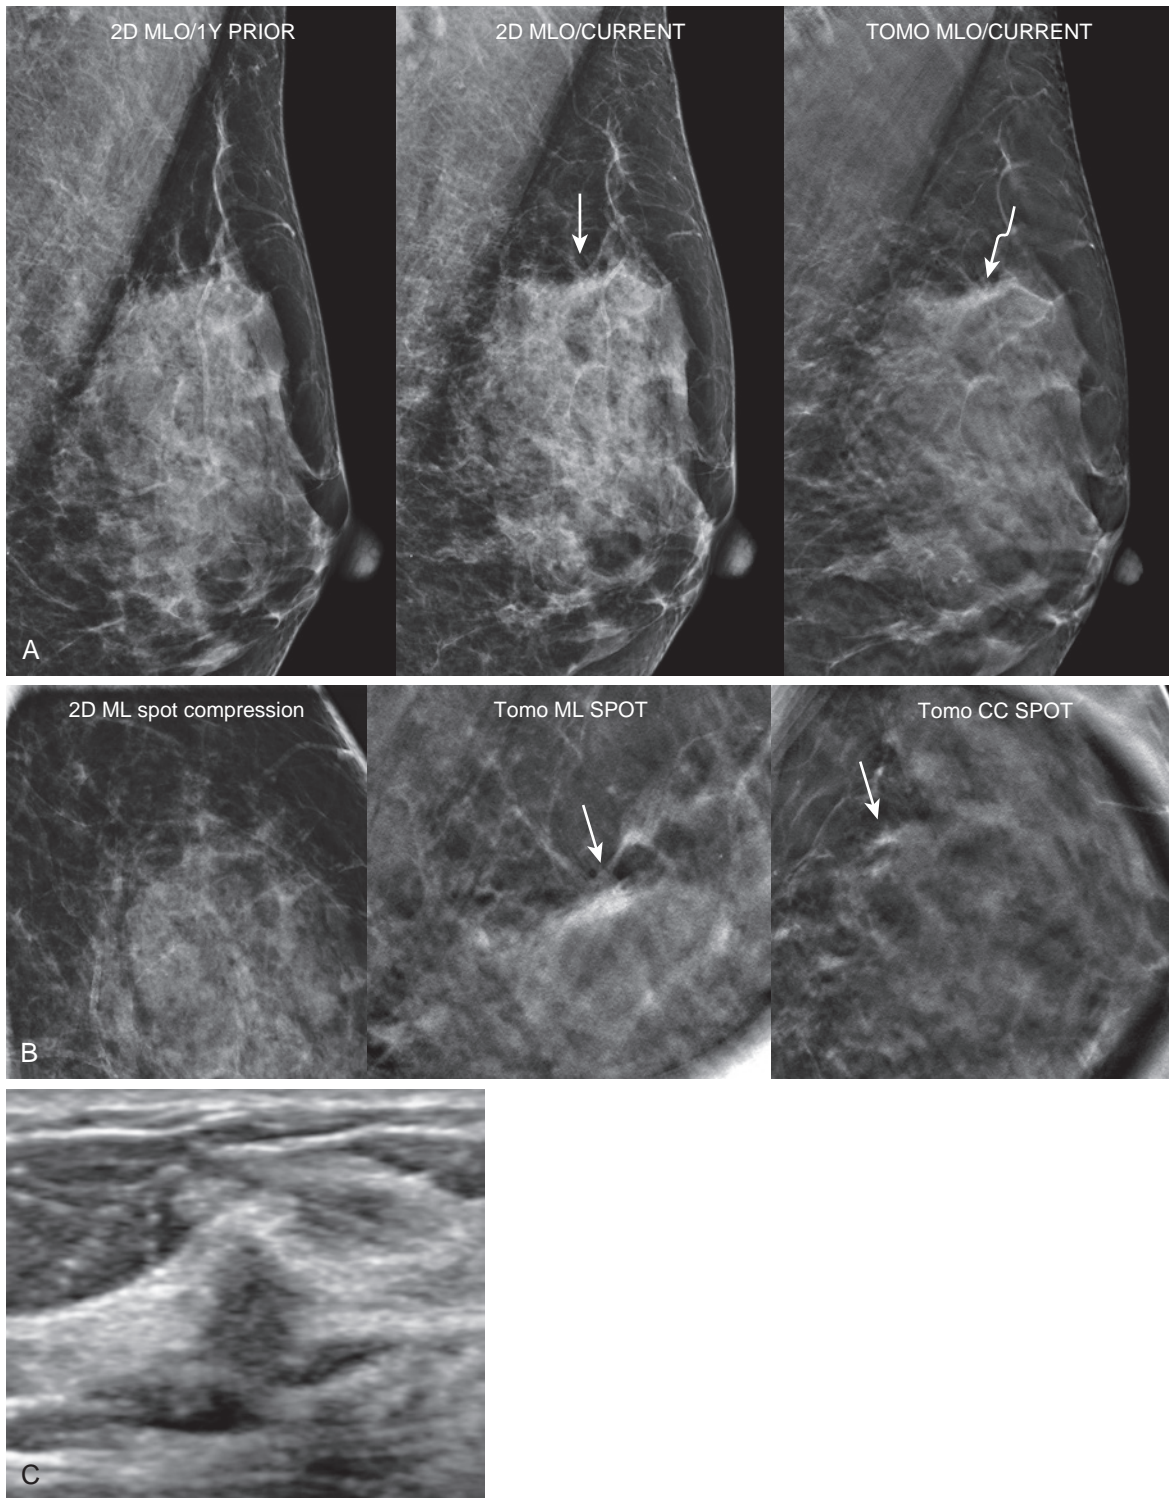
Two-dimensional spot compression is inferior to tomosynthesis spot compression in evaluation of a “tomosynthesis only” architectural distortion. (A) Yearly diagnostic mammogram in a 54-year-old woman being followed for a probably benign finding in the right breast (not shown). A new subtle straightening of the superior fat parenchymal border on the left 2D MLO (*arrow*). A corresponding subtle AD is seen on tomosynthesis (*curved arrow*). (B) Because the AD was subtle even on the initial tomosynthesis views, spot compression views were obtained. The 2D spot compression view is not useful, as the AD was only initially seen on tomosynthesis. Tomosynthesis spot compression reveals a very subtle AD, really only seen on the ML (90-degree lateral) view and not well seen on the CC view (*arrows*). (C) Targeted ultrasound demonstrates a corresponding irregular isoechoic mass with indistinct borders and an anti-parallel orientation. Ultrasound guided core needle biopsy and excision = 1.5 cm IDC, grade 1 tubular subtype, ER/PR+. Her2-. Ki67 = 1%, 0/1SLN.
